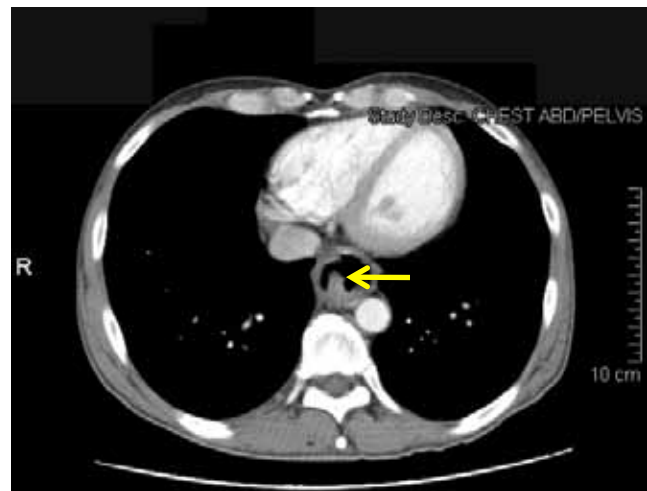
CT scan showing an esophageal tumor.
